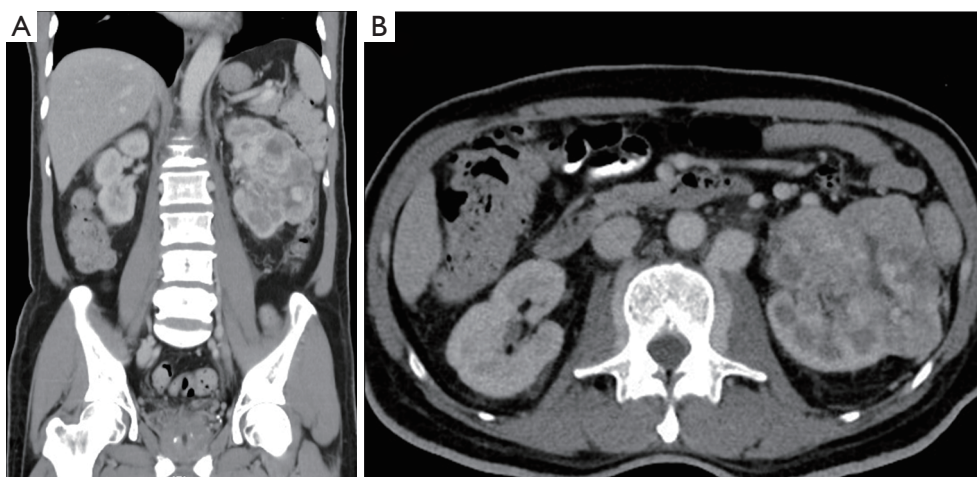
(A) Coronal and (B) axial CT images of the abdomen showing the renal mass and renal vein thrombosis.
